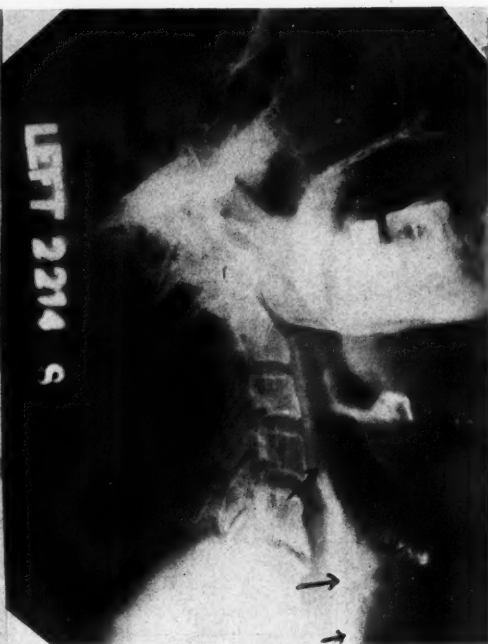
Roentgenogram of larynx before treatment.
